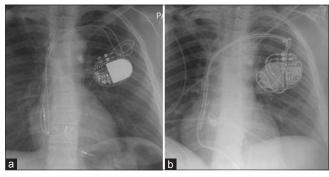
Posteroanterior chest radiograph demonstrating pacemaker. (a) Corresponds with nonmagnetic resonance imaging compatible device whereas (b) the new, magnetic resonance imaging compatible pacemaker in place
